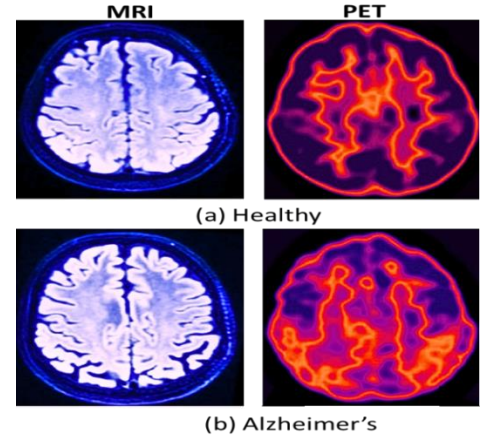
Samples of MRI and PET images: HC (top-row), AD (bottom-row)
